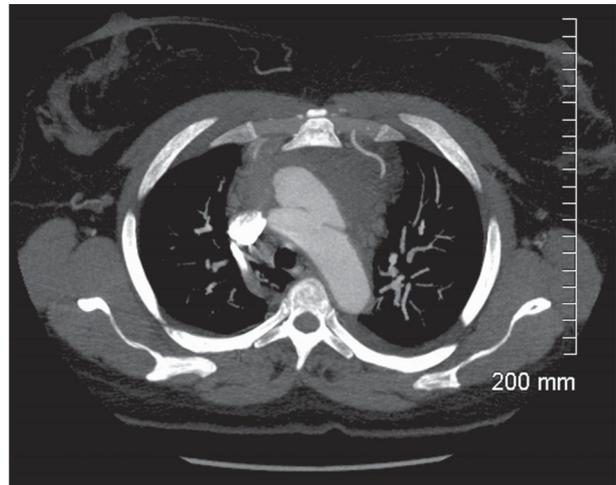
Transversal computed tomography scan view of dissection Stanford type A from aortic root to innominate artery.
